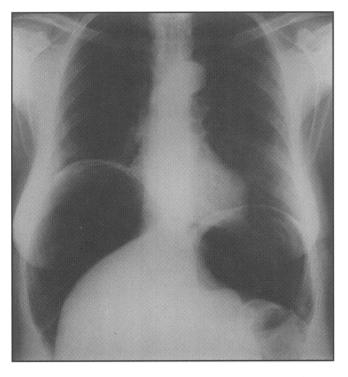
Plain erect abdominal X-ray demonstrating a massive pneumoperitoneum.
